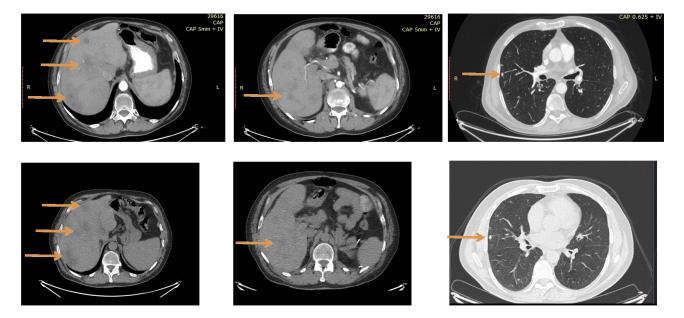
CT scans of patient 2. Upper line showing liver and lung lesions before therapy and lower line showing the same lesions after the administration of 6 cycles of Doxorubicin plus Olaratumab. Arrows highlight the lesions.
